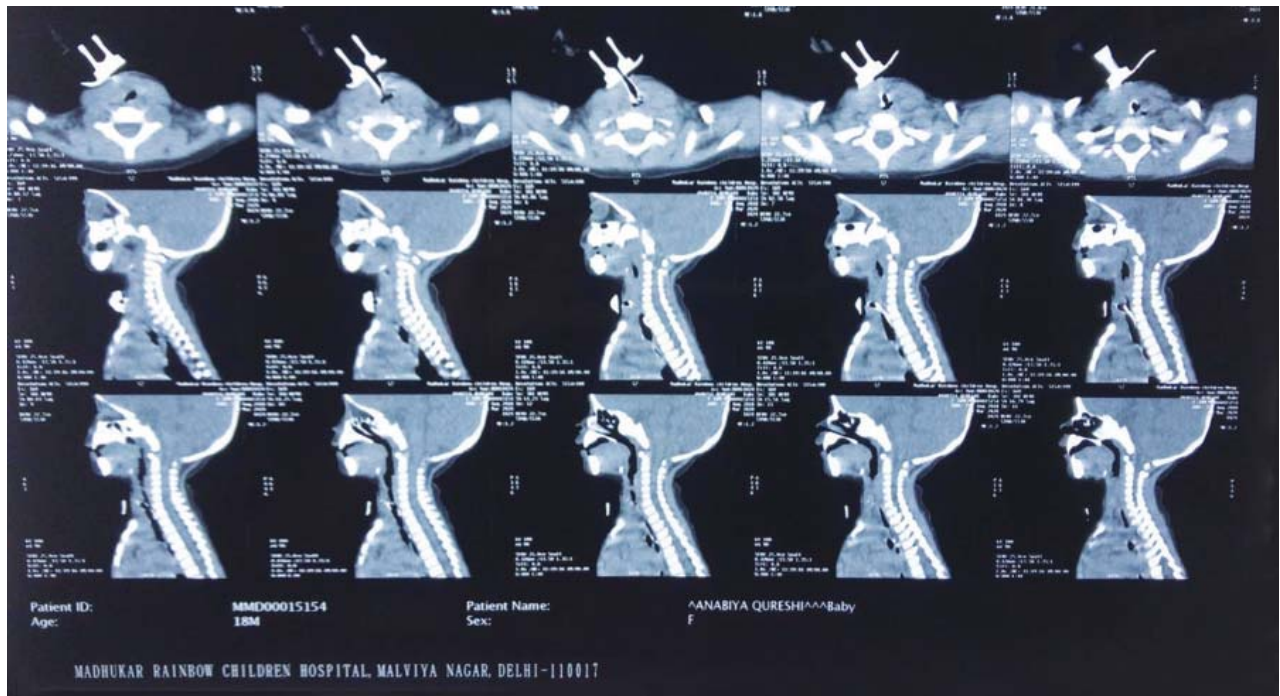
(a): Contrast enhanced CT neck and chest: Diffuse lung disease mostly ground glass type suggesting partial alveolar filling and greater interstitial involvement, with small subglottic stenotic segment with pinhole stenosis of airway.
